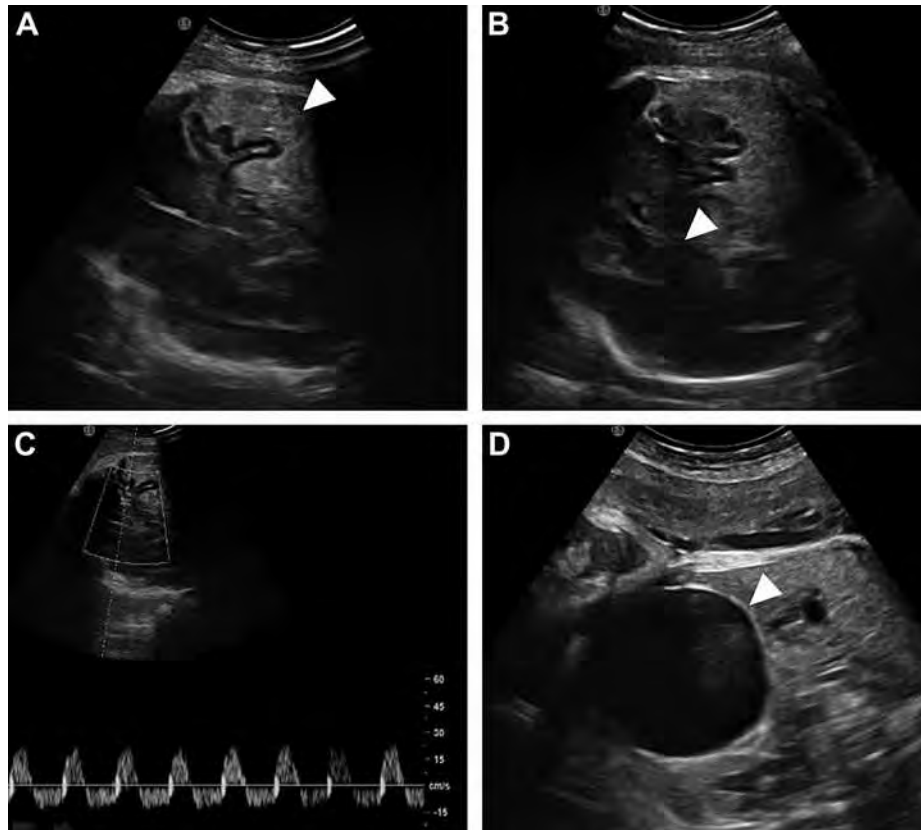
Doppler ultrasonography showed a massive intracranial hemorrhage in the axial view of the fetal head and the distended bladder. (A) Diffuse, but not well-defined hyperechoic area (arrowhead) in the right temporal lobe, indicating cerebral hemorrhage. (B) The intracranial hemorrhage resulted in a midline shift to the left side (arrowhead). (C) Duplex Doppler flow velocimetry showed reverse-end diastolic velocity of the right middle cerebral artery, which indicates increased intracranial pressure. (D) Persistent distended bladder of the fetus (arrowhead).
